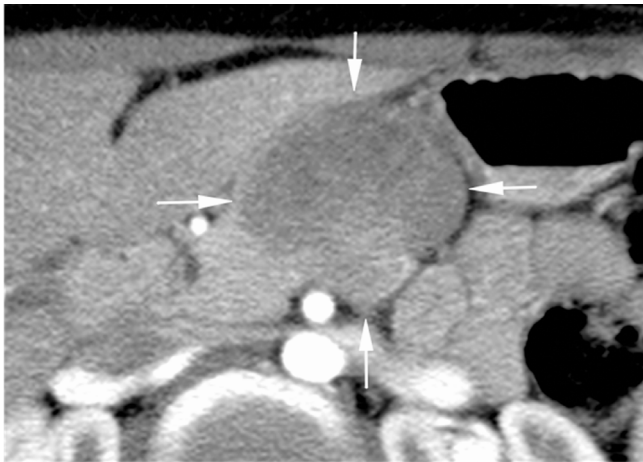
CT scan shows a large solid mass of pancreatic body and tail (arrows) that displaces nearby vascular structures.
